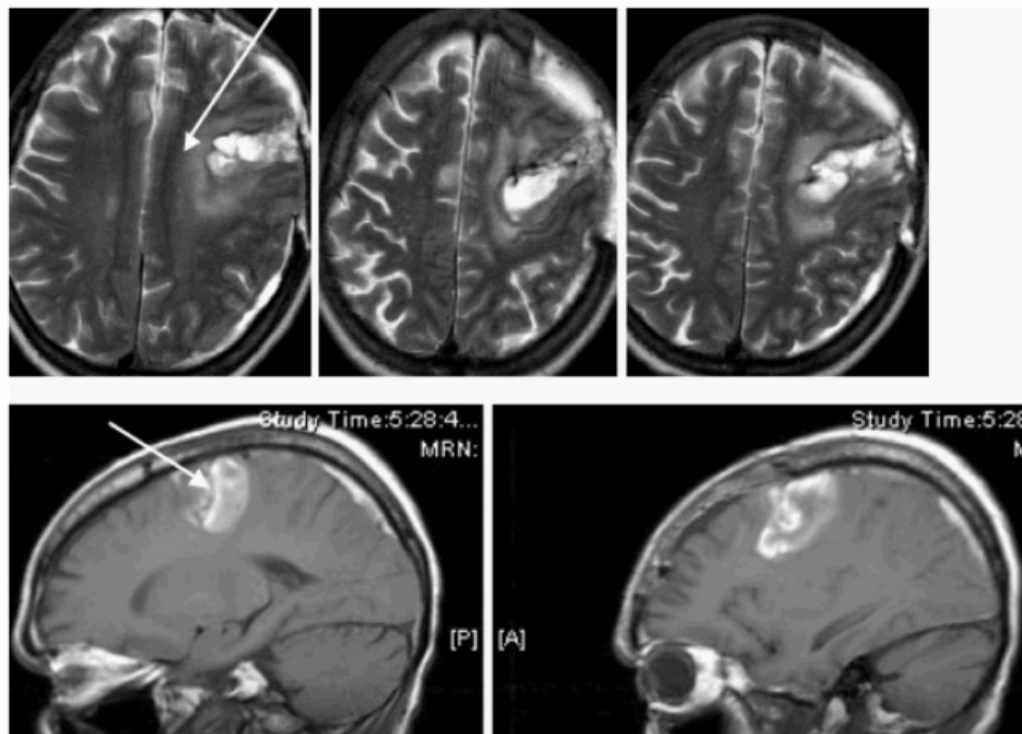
MRI at six weeks after hemorrhage and surgical evacuation of hemorrhage; upper row axial T2; note lesion extension medially to edge of cingulate gyrus (arrow); lower row T1 parasagittal; center of lesion in SMA (arrow) but deep extension involves middle frontal white matter. Cortical lesion extent does not capture the consequences of subcortical extension for local and distant disconnection of frontal pathways.
